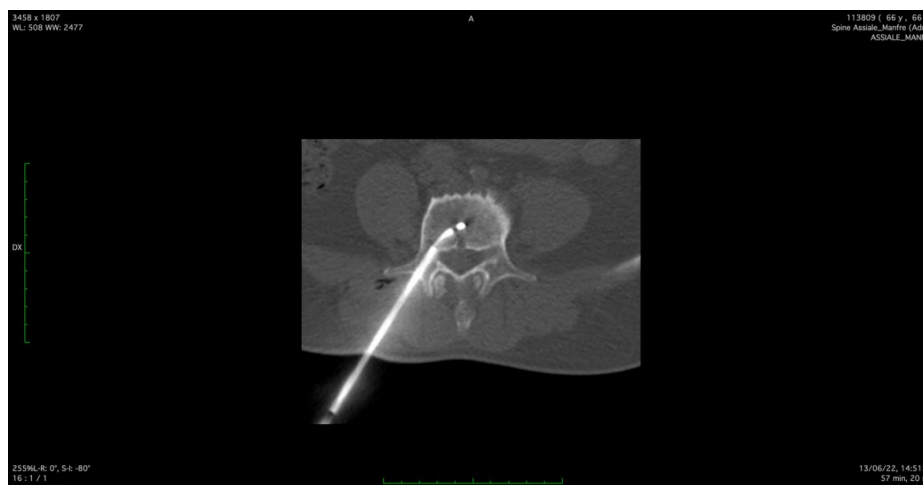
66-year-old male with chronic low back pain for 3 years. Basivertebral nerve ablation. CT-guided treatment was performed introducing a steerable radio-probe with a transpedicular approach inside L4 and L5, reaching the midline at the junction of the anterior 2/3 and posterior 1/3, exactly at the level of the basivertebral nerve rising area.
